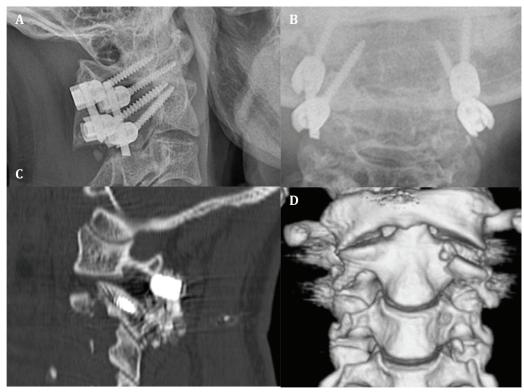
The 6-month postoperative radiography of atlantoaxial spine in lateral (A) and anteroposterior (B) views demonstrating complete reduction of the atlantoaxial rotatory subluxation (AARS), fusion of the atlantoaxial joint and appropriate instrumentation. The sagittal computed tomography (CT)-scan of the atlantoaxial joint through left facet demonstrating complete reduction (C). The postoperative coronal 3D reconstruction CT-scan of the patient revealing complete reduction of the AARS.
